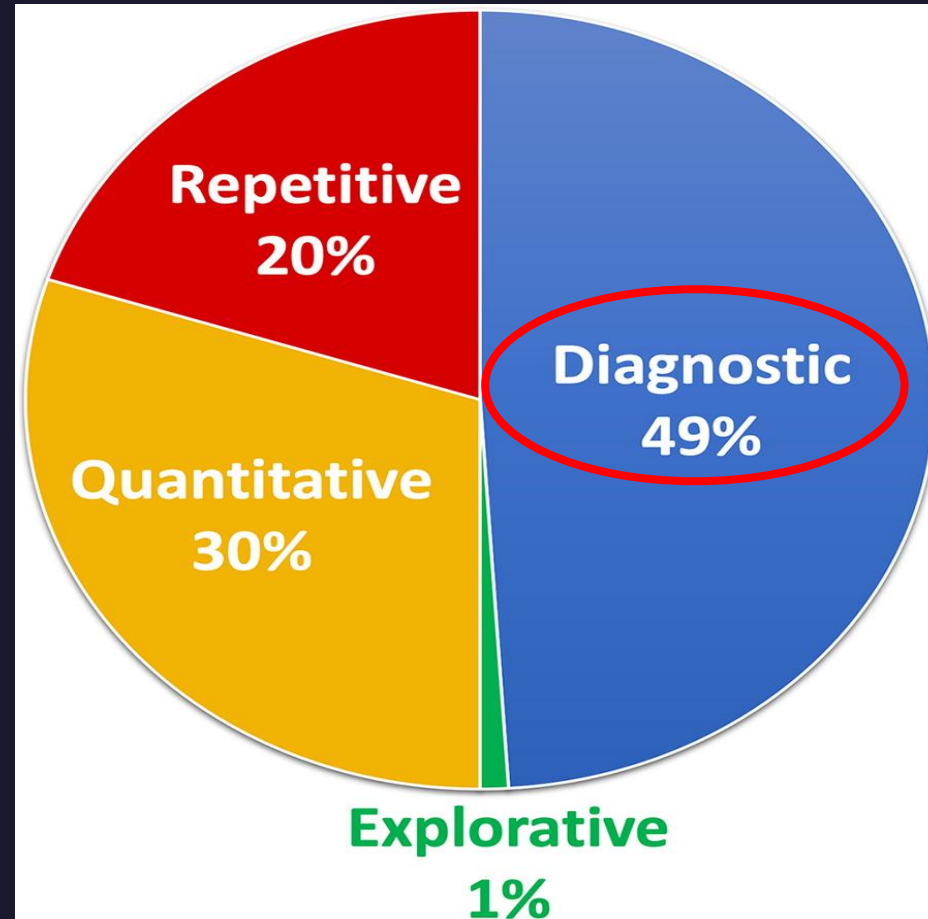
Artificial intelligence companies by type of task (repetitive, quantitative, diagnostic, or explorative) of 119 software offerings. Repetitive tasks mainly target high-volume, low-complexity tasks such as lung nodule detection or tracking of multiple sclerosis lesions. Quantitative tasks include measuring volume of emphysema on chest CT images or measuring bone density. Explorative algorithms are designed to allow a radiologist to select an area of interest on an image and return similar-appearing regions from other scans with associated diagnoses. Last, diagnostic tasks cover the majority of remaining algorithms and include functions such as detection of pneumonia on chest radiographs, classification of breast lesions, and grading of liver tumors.
